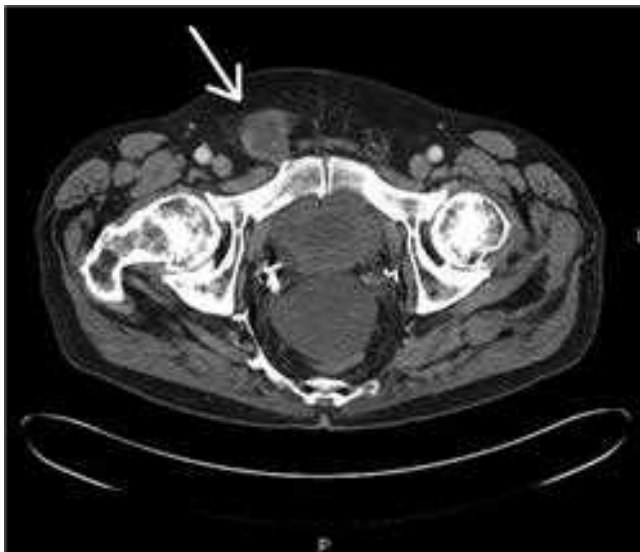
Computed tomography scan depicting a large right inguinal hernia (*arrow*). A smaller left inguinal hernia is also visualized.
